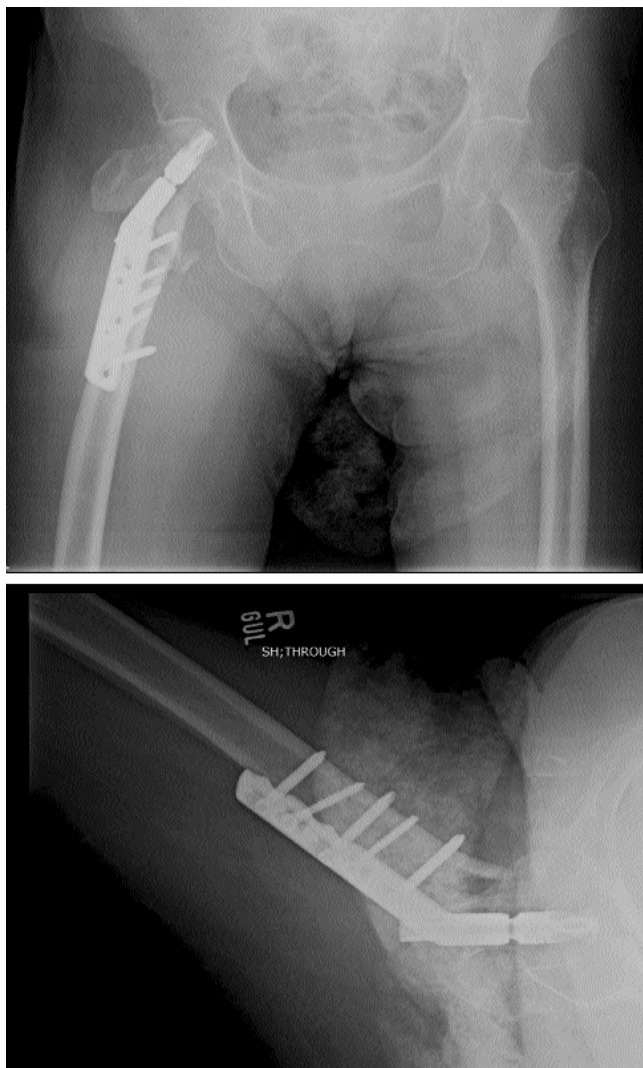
X-rays of implant Cut-out 4 due to infection.
